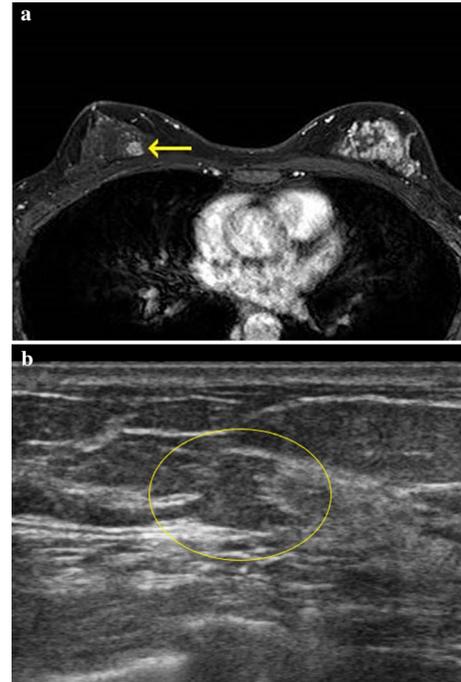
A 47-year-old woman with cancer in the left breast. a Post-contrast MRI reveals focal non-mass enhancement (arrow) in the right breast. b The MRI-detected lesion is identified on second-look ultrasonography
